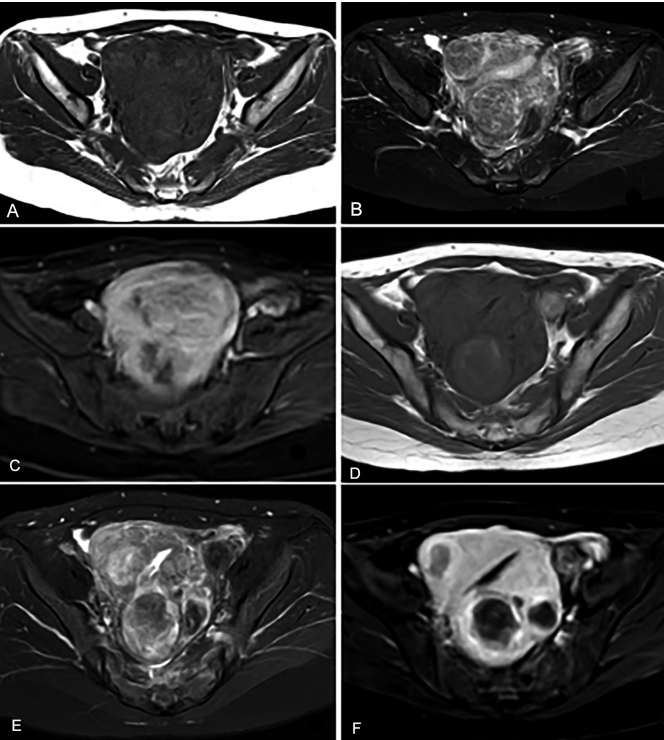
A 30-year female patient had multiple uterine fibroids for more than three years. (A-C) Before the HIFU treatment, multiple fibroids were identified in the myometrium, showing equisignal on T1WI and slightly high intensity in T2WI-STIR. The dynamic contrast-enhanced scan demonstrated significant enhancement, comparable to the degree of myometrium enhancement. (D-F) After the HIFU treatment, the fibroids appeared slightly higher on T1WI and showed mixed high- and low-intensity signals on T2WI-STIR. On the DCE-MRI, unenhanced liquefaction necrosis areas were observed in the central part of the lesion.
